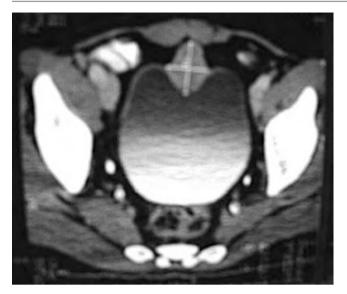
CT Scan showing solitary urachal tumour apparently confined to bladder wall (about 3 cm diameter)
